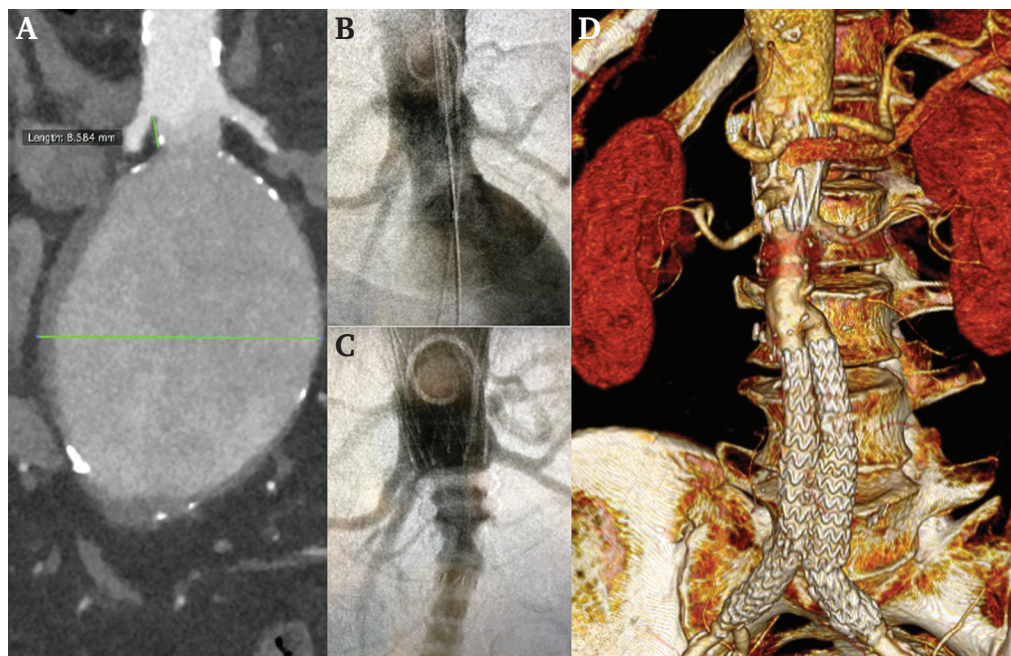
Endovascular aneurysm repair with the Ovation Alto endograft. (A) Computed tomography angiography (CTA) scan of a 9 cm AAA with hostile proximal neck and highly calcified bilateral iliac access. (B) Intra-operative fluoroscopy highlighting the complex aortic neck. (C) Final angiogram revealing the accurate deployment of Ovation Alto endograft, good patency of renal arteries, and no high flow endoleak. (D) 3D volume rendering of one month CTA follow up shows the correct exclusion of the aneurysm sac with good proximal sealing.
